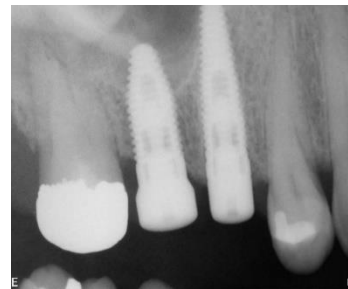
X-ray after implant placement
